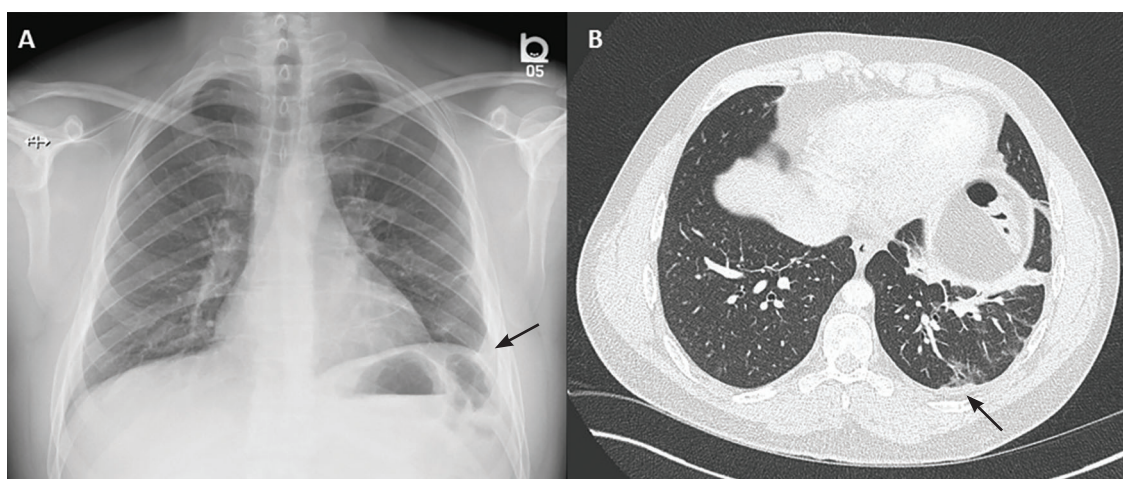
Chest radiography in the emergency department (A) showed a mild left-sided pleural reaction (arrow). Computed tomography (B) showed a mild pleural reaction (arrow) and parenchymal atelectatic and fibrotic changes.
